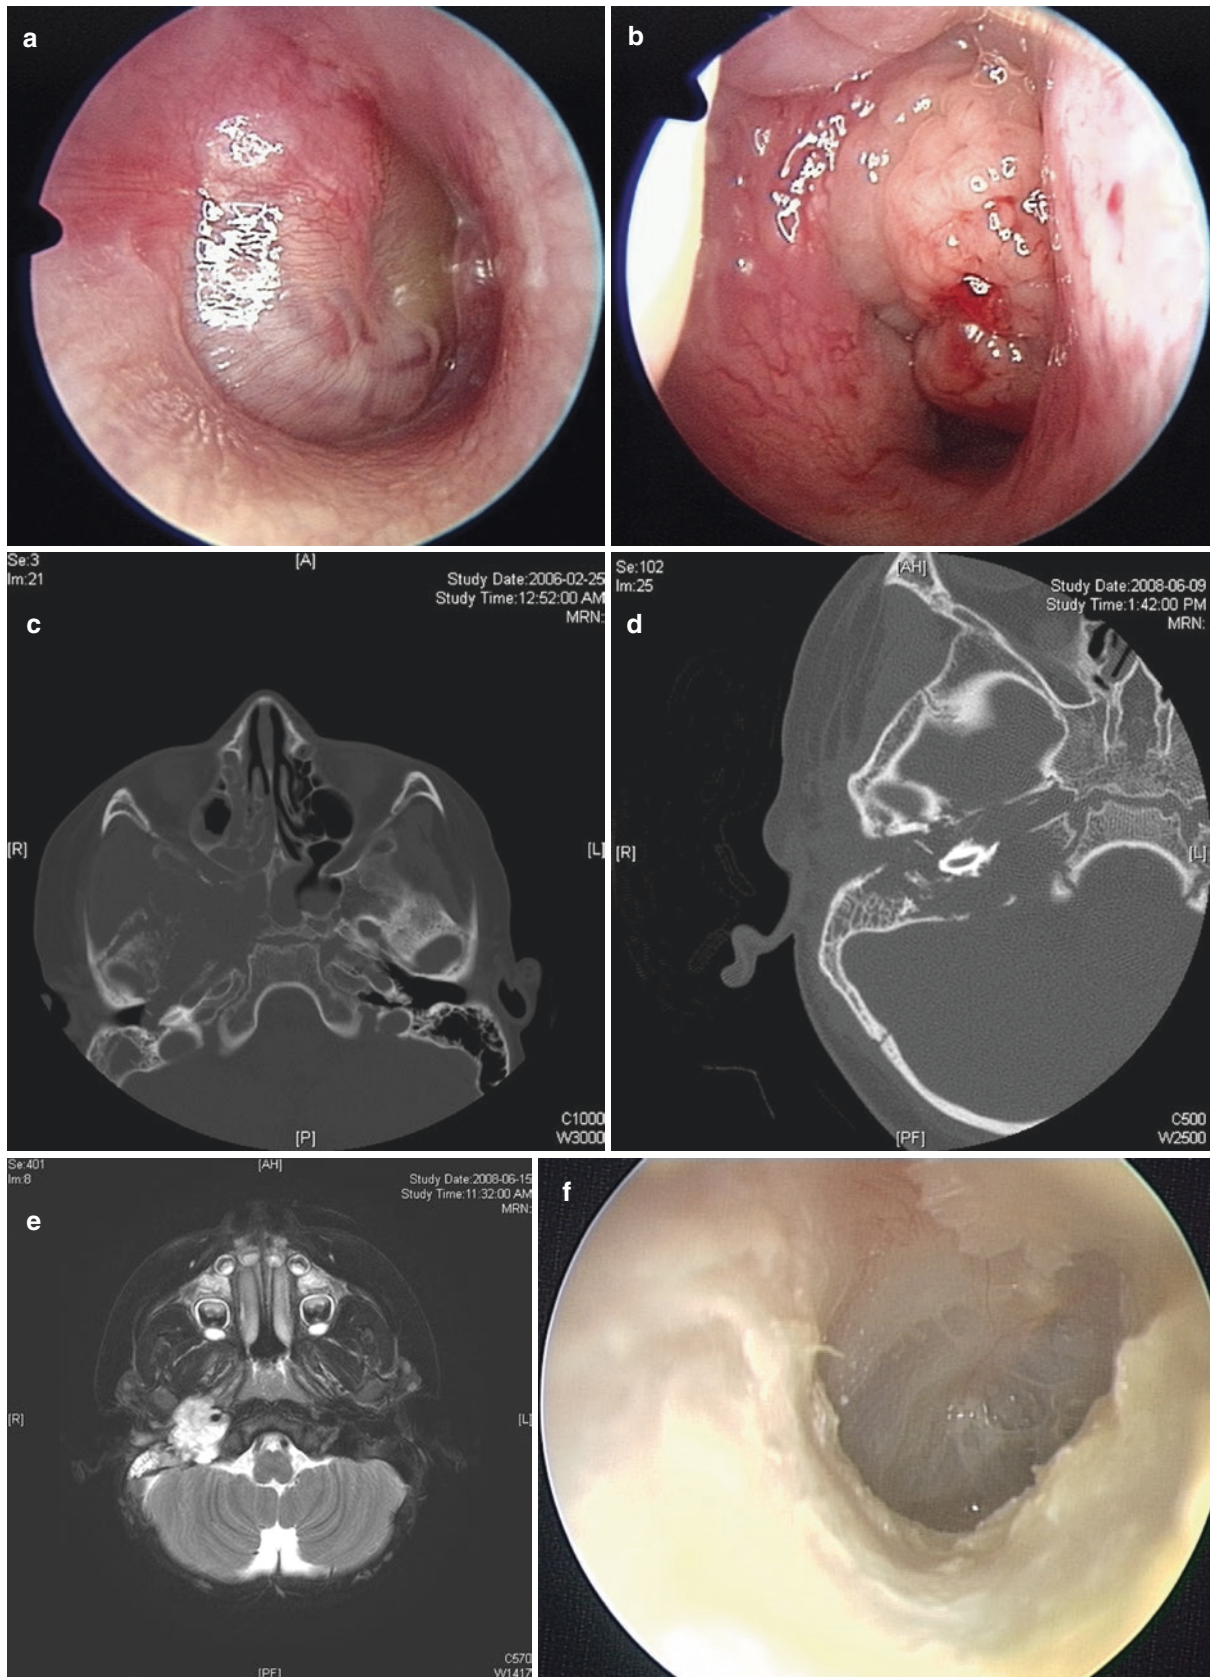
(a) Otoloscopy showing mass behind right tympanic membrane. (b) Rhinoscopy showing mass in postnasal space. (c) Axial CT showing extensive destruction of bone at skull base. (d) Axial CT showing extensive destruction of temporal bone. (e) Axial MRI showing
